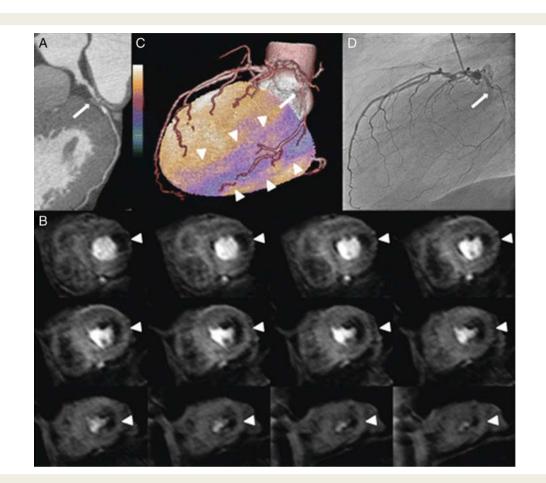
The hybrid images can also be created by fusion of images from coronary computed tomographic angiography and cardiac magnetic resonance. A 65-year-old male patient with typical chest pain underwent low-dose coronary computed tomographic angiography for evaluation of coronary artery disease. (A) On CT angiography a high grade stenosis of the first large obtuse marginal branch (OM1) could be seen. Subsequently, a stress cardiac magnetic resonance perfusion imaging (adenosine 140 μ g/kg/min, 0.1 mmol/kg Gadobutrolum, kt-SENSE) was performed with a new sequence allowing three-dimensional perfusion assessment. This revealed a lateral perfusion defect, involving 13% of the left ventricular myocardium (*B*, white arrowheads). The three-dimensional hybrid images showed a perfect match of the perfusion defect (white arrowheads) and the culprit lesion (white arrow) (*C*), documenting a prognostically important finding requiring revascularization. A 50% stenosis of the proximal left anterior descending artery was not associated with any perfusion defect on three-dimensional hybrid. Finally, the patient underwent invasive coronary angiography confirming a subtotal occlusion of the OM1 (*D*, white arrow) which was successfully revascularized. On clinical follow-up, the patient was well and reported no further anginal episodes (adapted with permission from Manka et al.⁶²).
